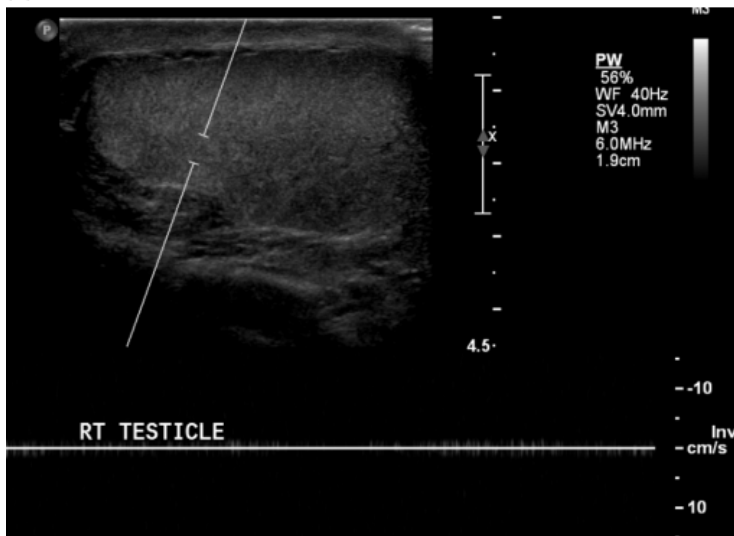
(a) Testicular torsion of the right testicle with loss of power Doppler signal and enlarged size. The echotexture appears preserved, suggesting that the torsion is early in presentation. (b) Spectral Doppler with no detectable arterial or venous flow in a case of testicular torsion.
